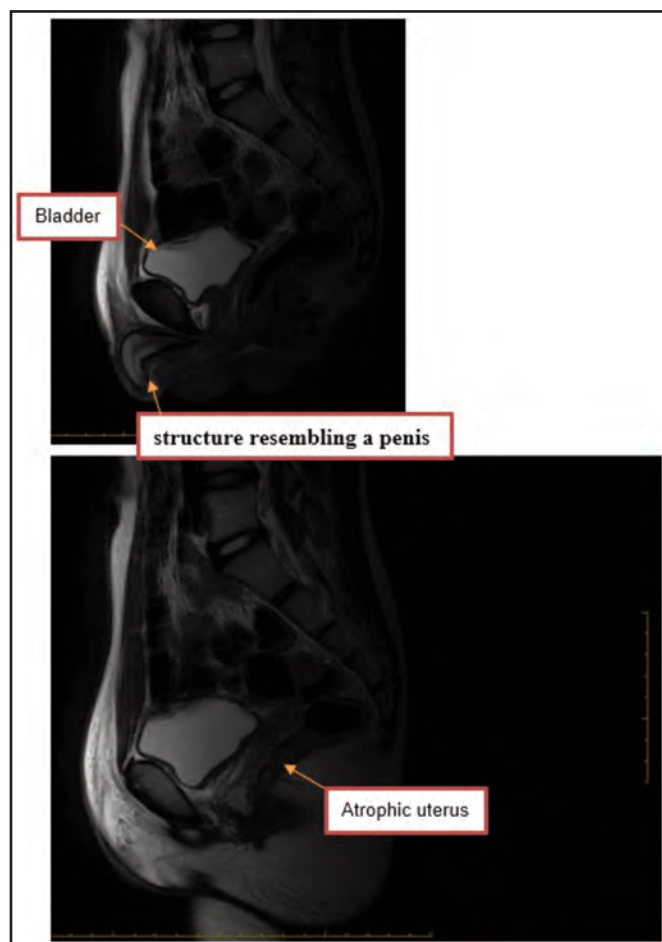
Sagittal T2-weighted MRI: Shows the atrophic uterus (2.7 × 1.7 × 2.8 cm) with single endometrial cavity and preserved zonal anatomy
